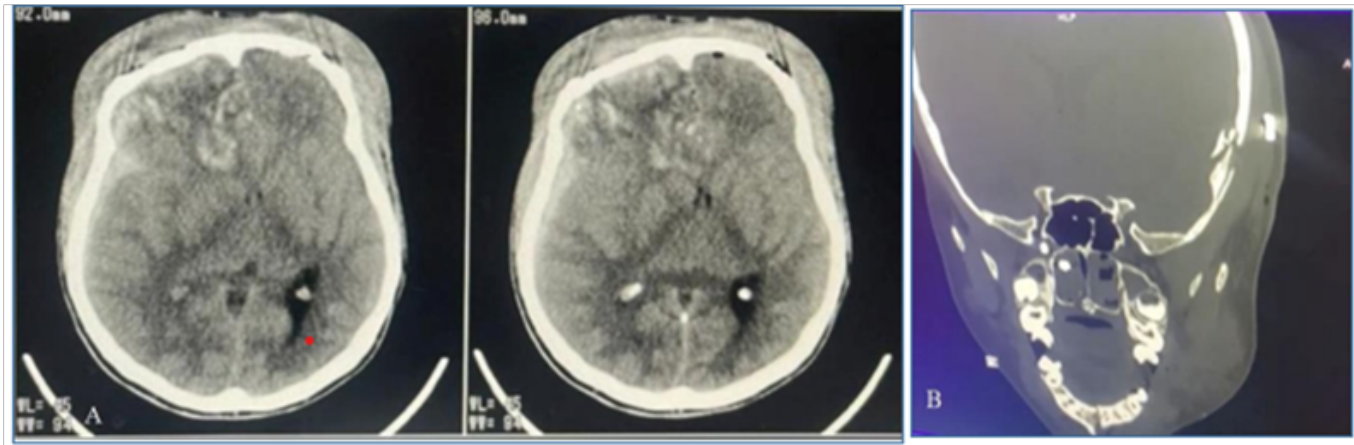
CT scans for patients with concomitant head and maxillofacial trauma.
